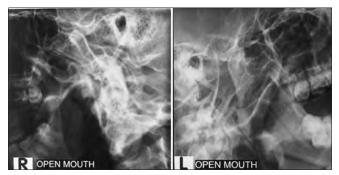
Right and Left open mouth transcranial view radiograph showing the unequal excursion of the condyles on the open mouth position
